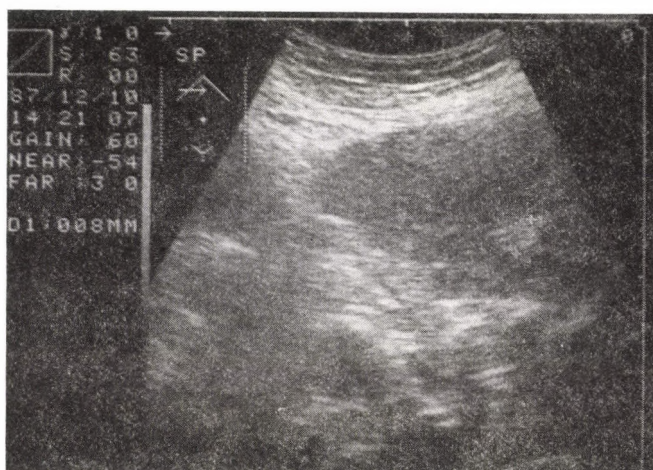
Sonographic scan of liver metastasis
